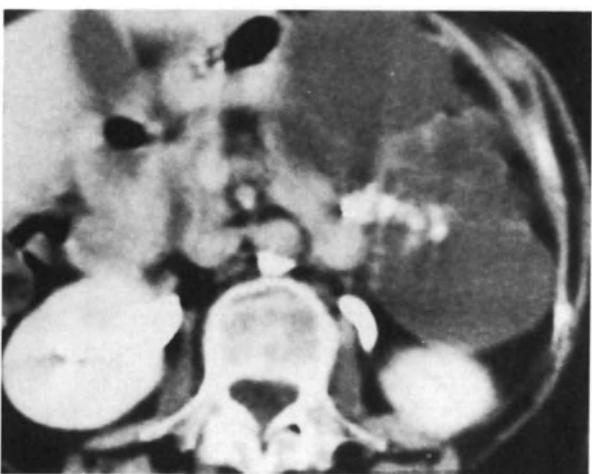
CT scan enhanced. Calcification in mucinous cystadenoma arising in the tail of the pancreas.
